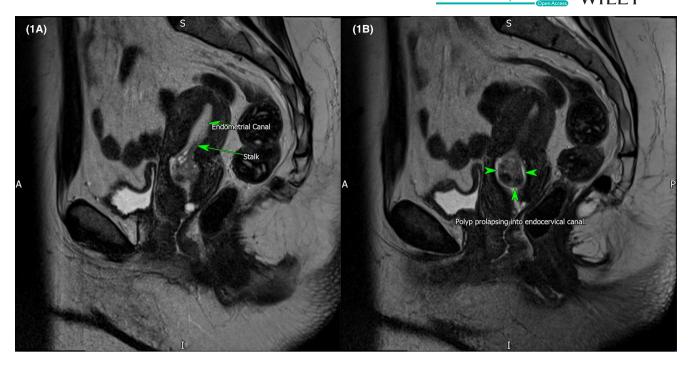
Sagittal T2 weighted MRI sequence showing incidental polyp with stalk arising from the lower endometrial cavity (A) and prolapsing into endocervical canal (B).
